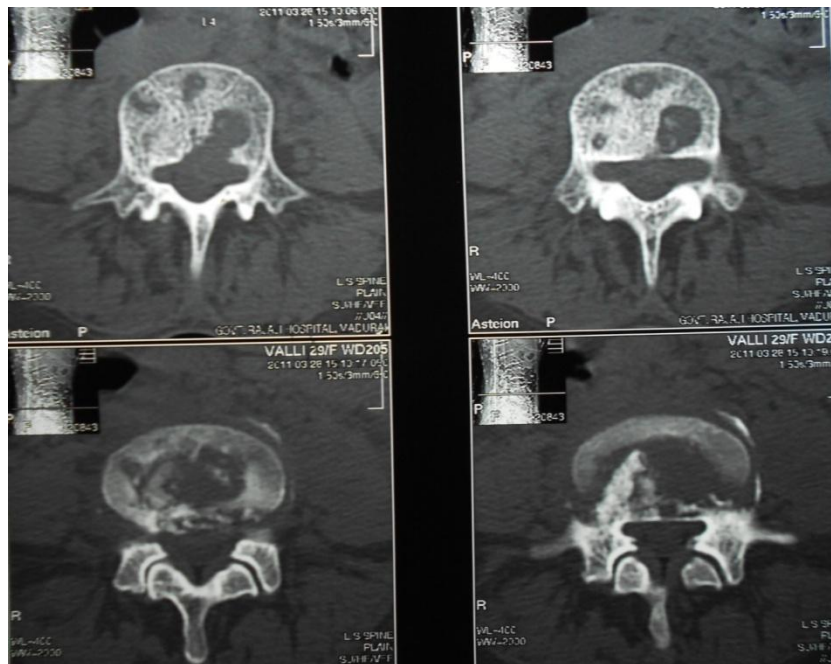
CT of D12-L1 Tuberculosis of spine
